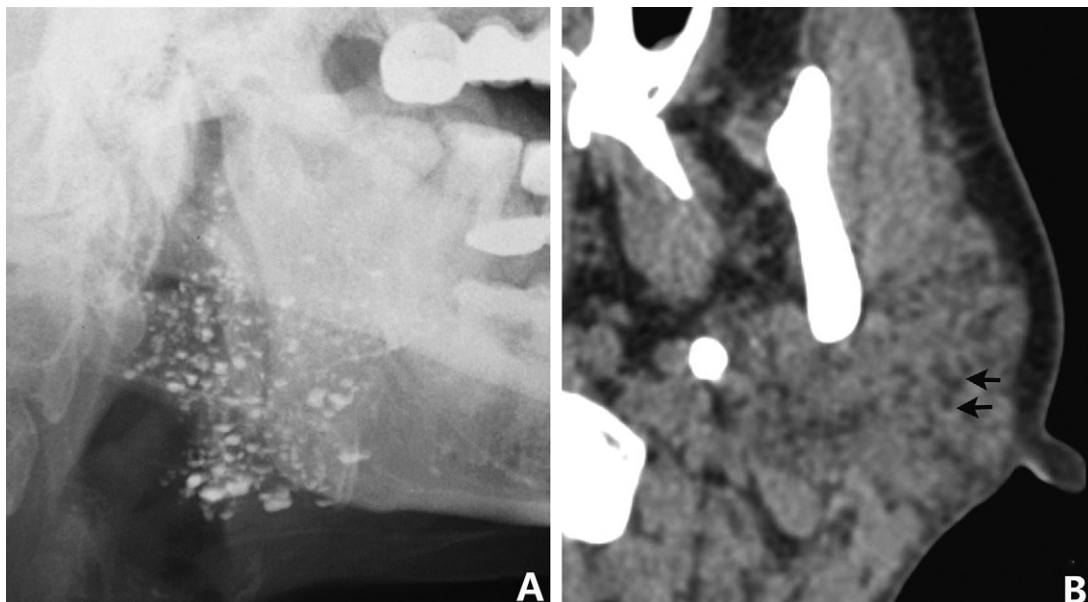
Sialogram and CT in stage 2 of SS. Globular sialectasia observed in a stage 2 patient (A) and the round (more than 2 mm in diameter) to irregular areas of adipose tissue accumulation in the parotid gland (B, white arrows) in the same patient (51-year-old, female).
